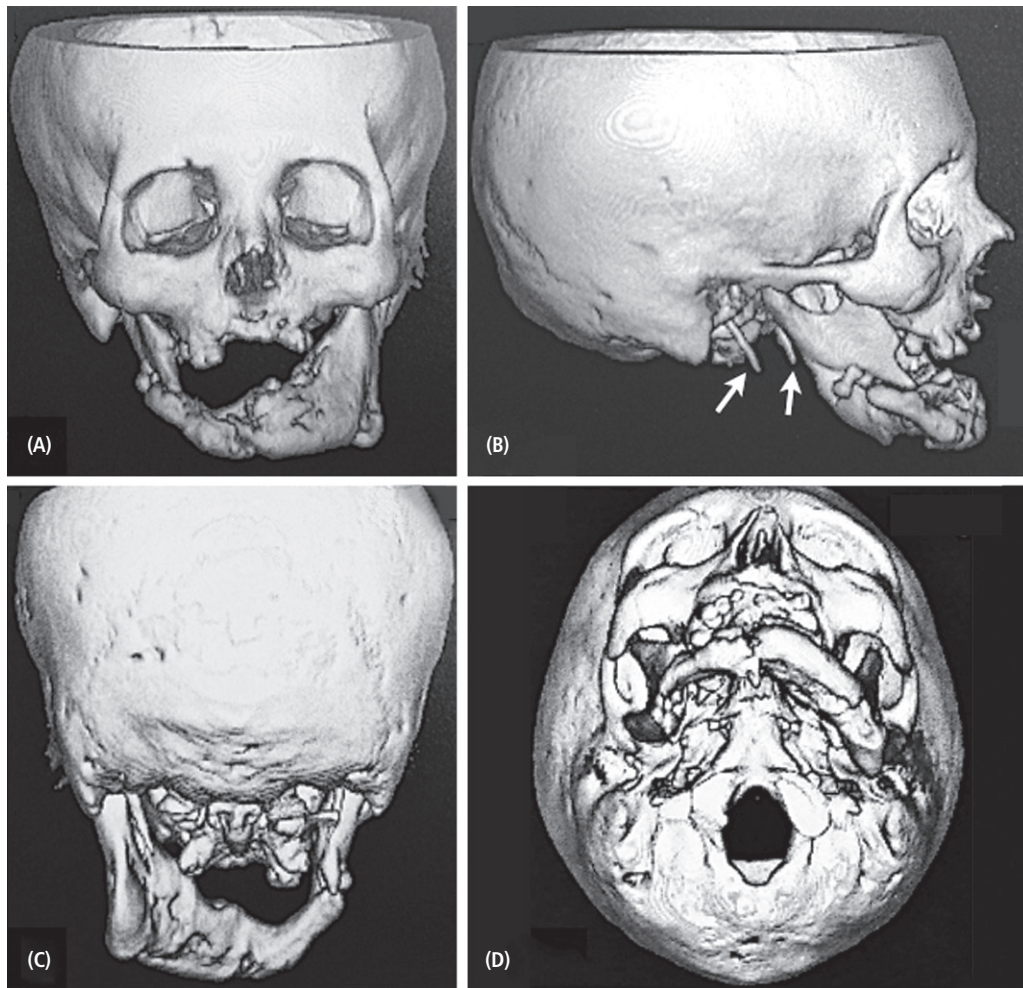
Three-dimensional computerized tomography (3D-CT) of the skull taken at age 24 years. Note the fracture of the mandible that was subsequently removed on the right side and the elongated styloid processes (arrows).
